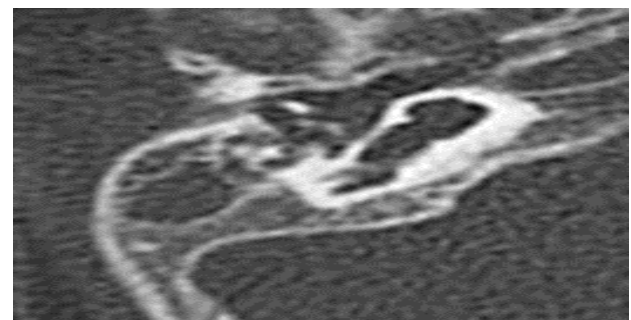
The appearance of incomplete partition Type-I in Temporal HRCT
